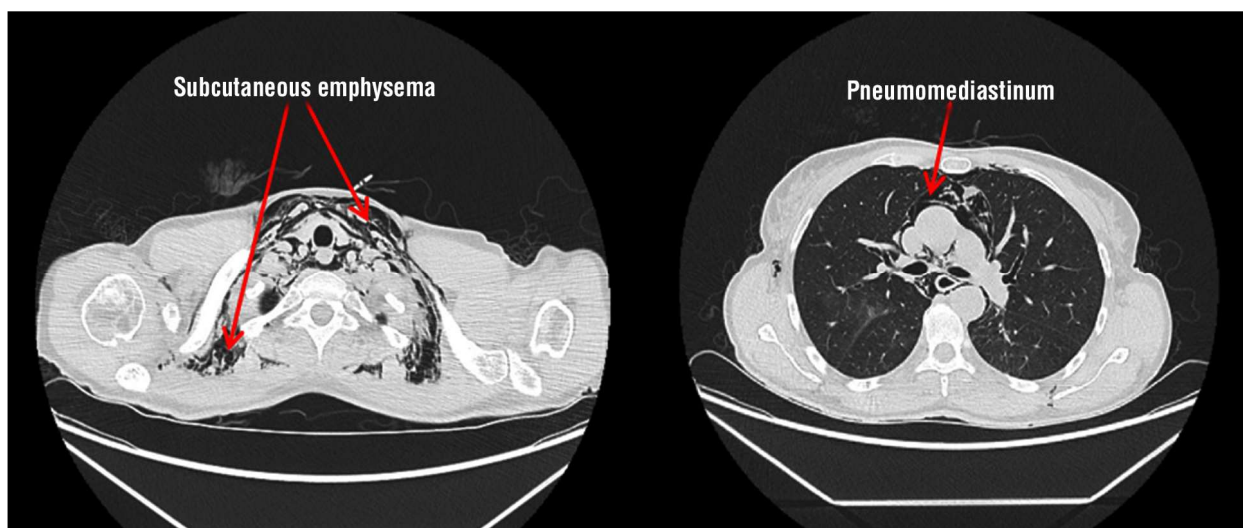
Preoperative CT showing subcutaneous emphysema and pneumomediastinum
